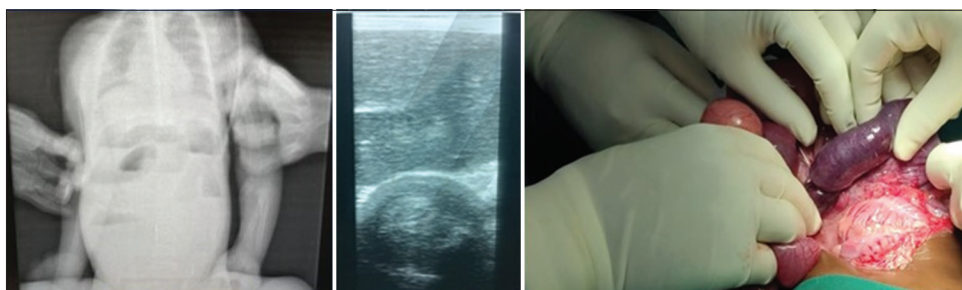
X-ray, ultrasound, and intraoperative findings of case 3
